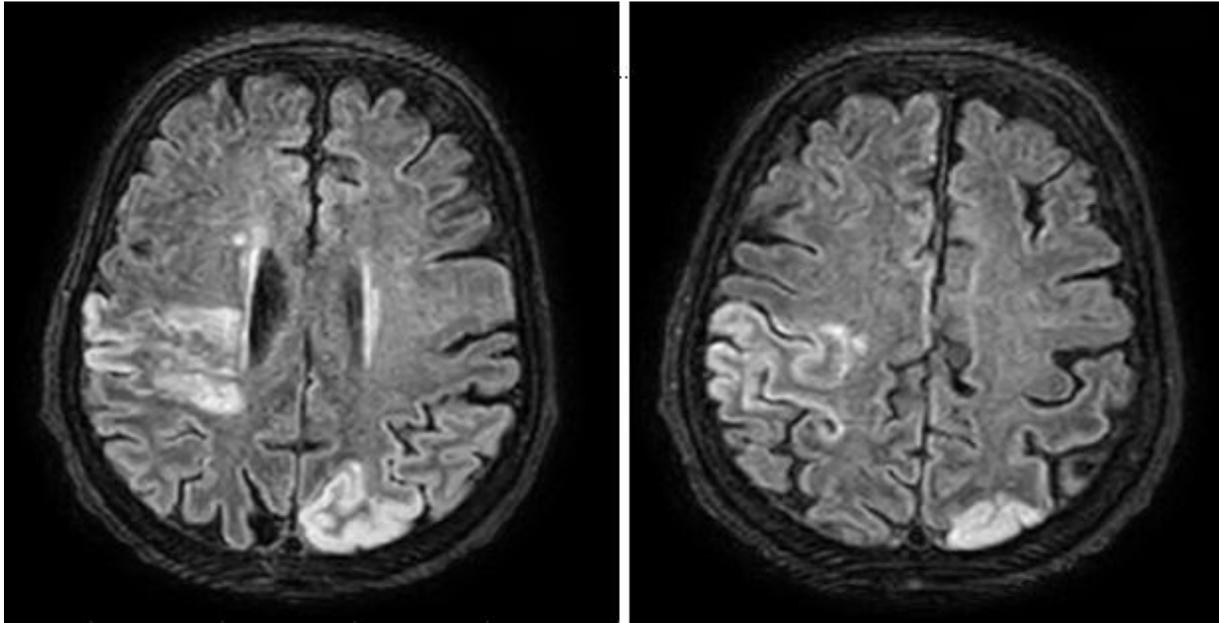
MRI showing a infarction area in the territory of the right medium cerebral artery and the left posterior cerebral artery.
